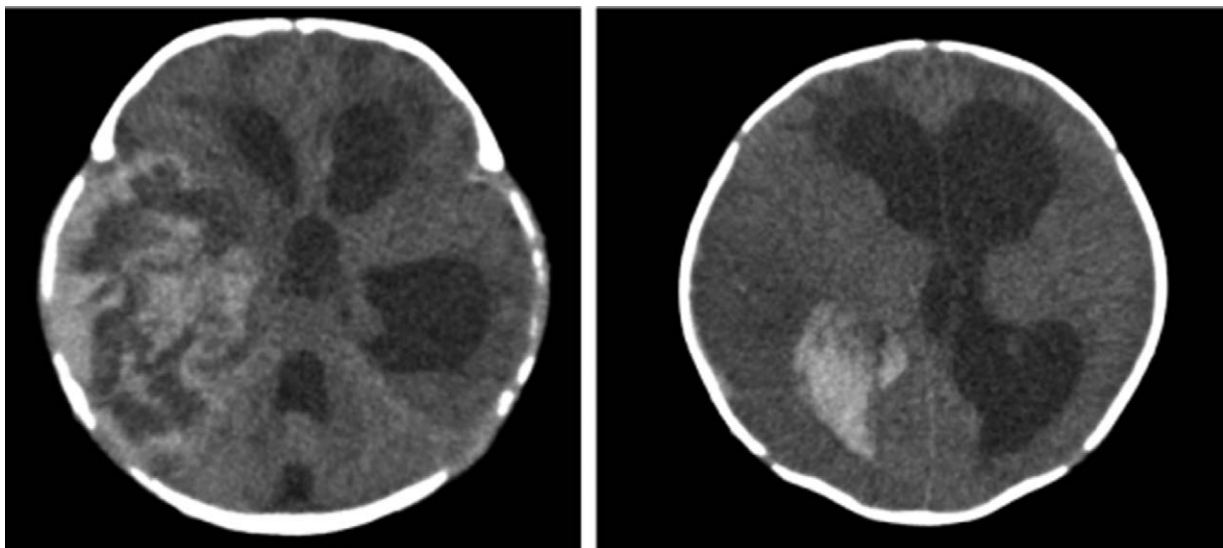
Head computed tomography scans of a female neonate admitted for bloody stool and fever (case 1). Hemorrhage is noted in the left temporal lobe, with invasion into the supratentorial ventricle, which appeared dilated and filled with blood (especially in the left ventricle).
